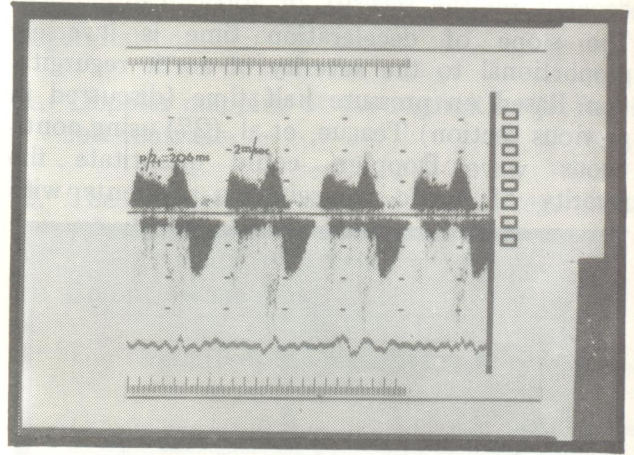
Continuous wave Doppler recorded from the apical view across the tricuspid valve. Appreciate the markedly increased pressure half time (arrow heads) which measured 206 milliseconds suggestive of severe tricuspid stenosis. This patient had carcinoid heart diseases. (Mitral Valve was normal).
